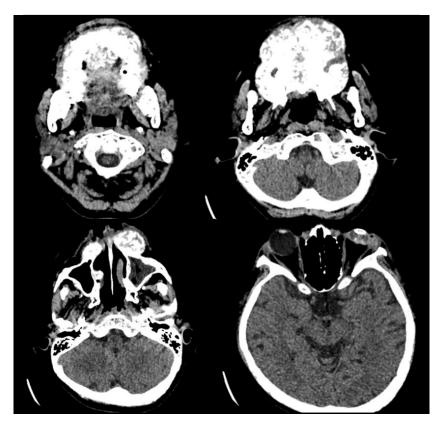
Multiple slices computed tomography scan (MSCT) of the head. MSCT revealed a mixed lytic and sclerotic calcified mass on the anterior part of left maxillary bone sized  $3 \times 2 \times 2$  cm, abnormal mixed lytic and sclerotic appearance of the calvaria, maxillofacial, and cervical bone, and calcification of the left eye lens with reduced eye bulb size.
